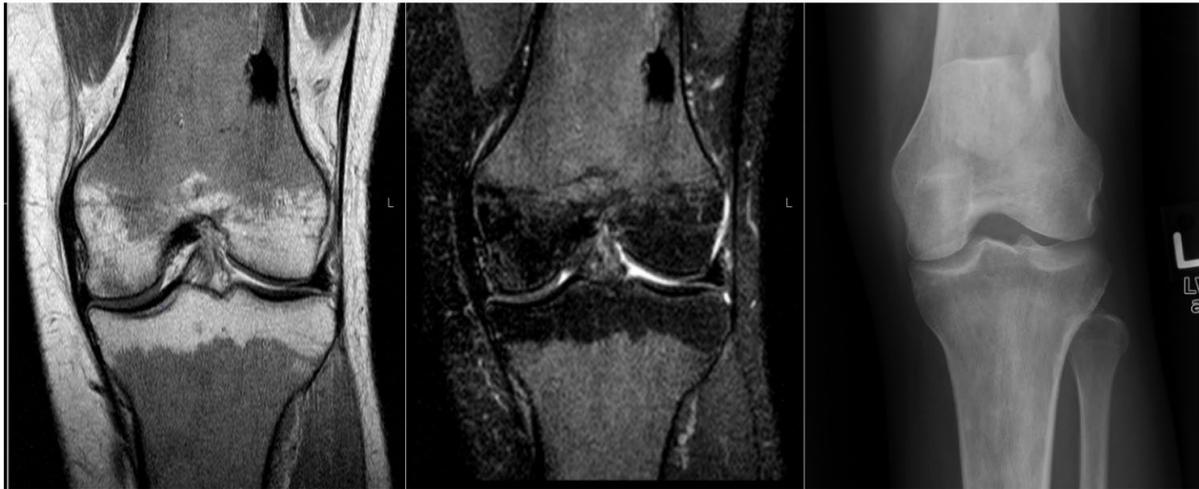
A, B - Left knee MRI with and without contrast - red marrow expansion into the epiphysis of the distal end of the left femur (yellow arrows). C. Left knee X-ray - no significant findings.
